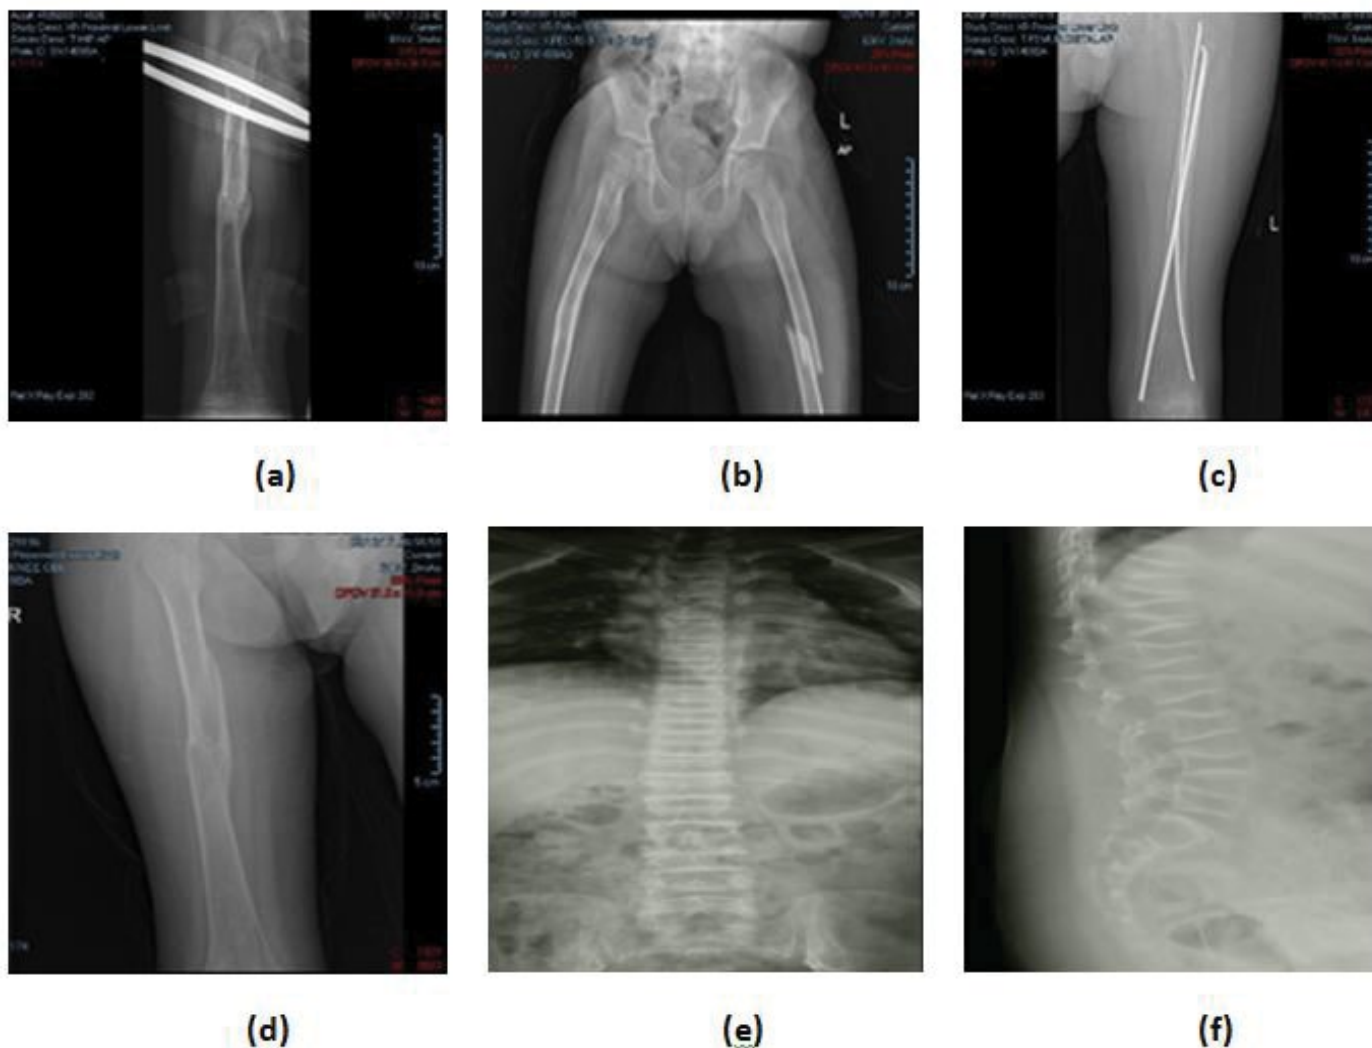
X-rays showing fractures and re-fractures of the boy's long bones (right and left femur) and lumbar vertebrae.
